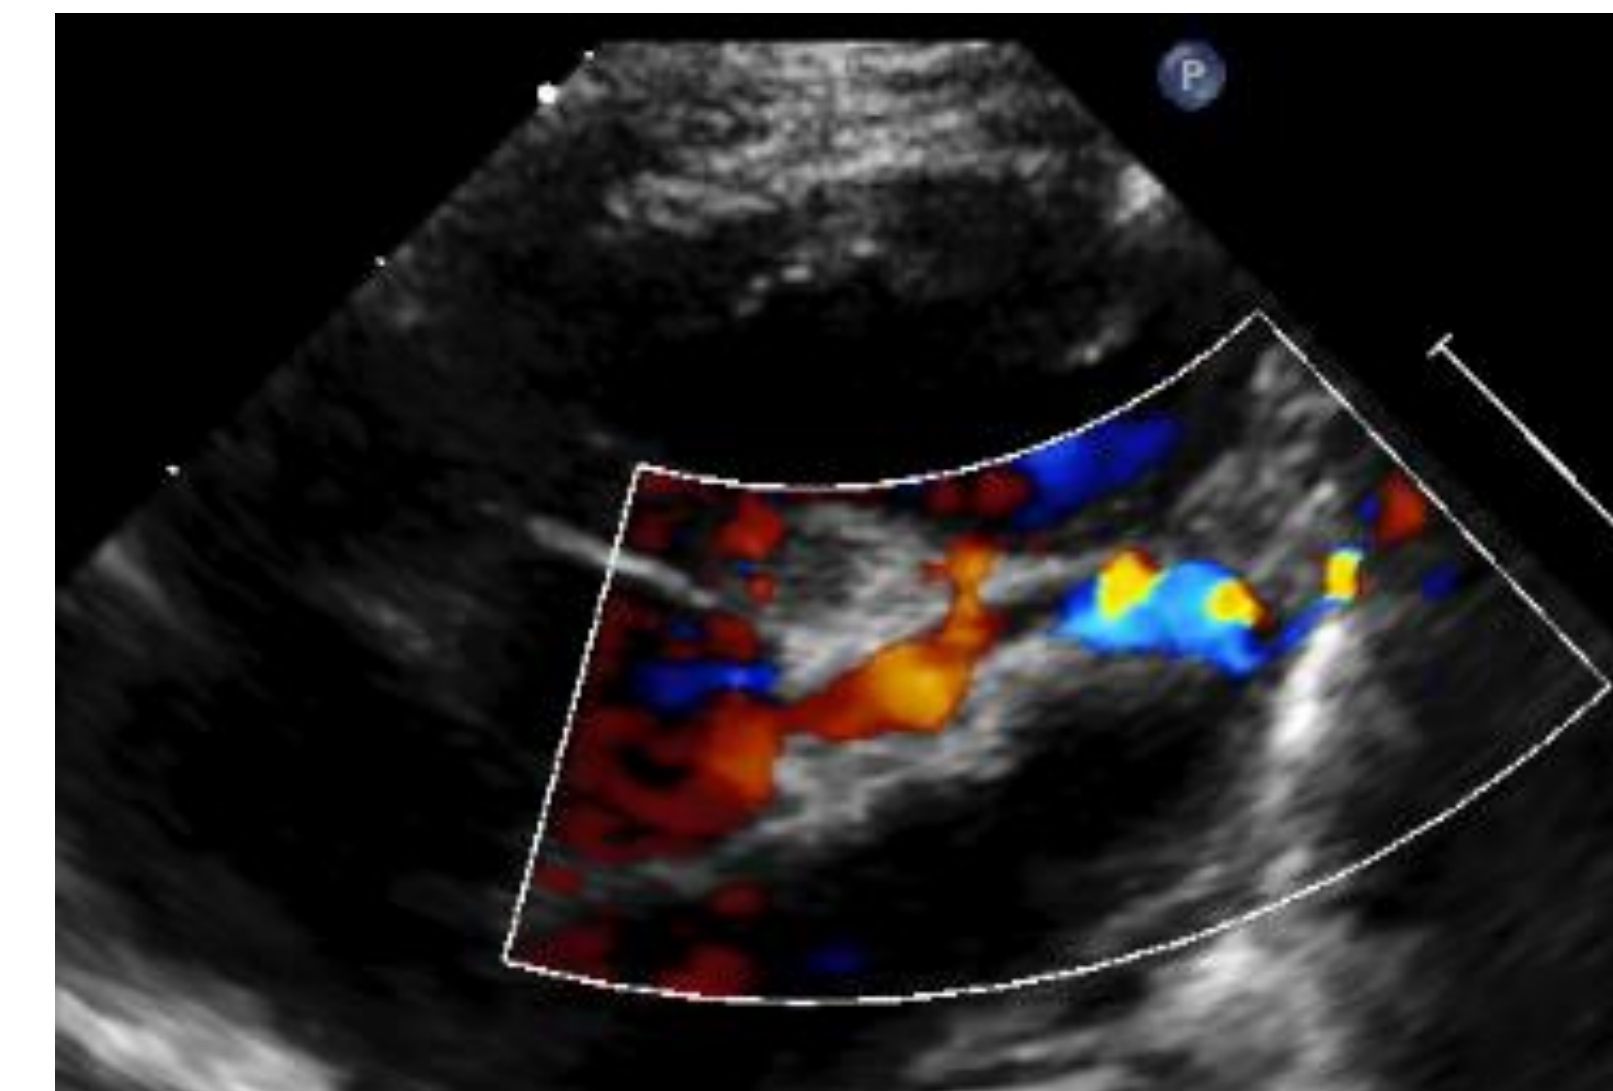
Transthoracic echocardiogram, parasternal short axis color doppler. The left main coronary artery and left anterior descending are dilated. Multiple fistulous connections to the right ventricle were present.
